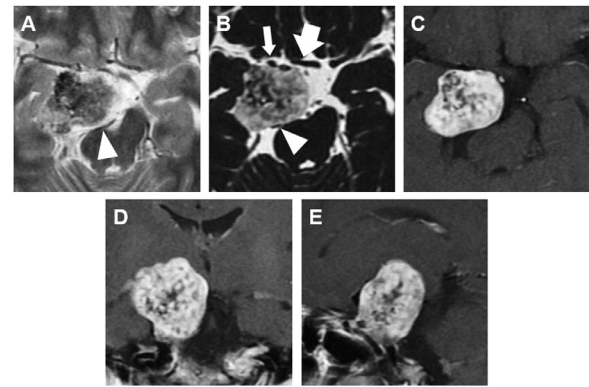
Magnetic resonance imaging performed 7 years after the initial study. T2-weighted (A; axial, B; axial thin slice) and gadolinium-enhanced T1-weighted images (C; axial, D; coronal, E; sagittal) show that the lesion had grown in size to 38 × 25 × 34 mm. The lesion shows iso- to hypointensity on T2-weighted imaging (A). The right posterior cerebral artery (A; arrowhead) and oculomotor nerve (B; arrowhead) were displaced posteriorly, whereas the right internal carotid artery (B; thin arrow) and optic chiasm (B; thick arrow) were displaced anteriorly
